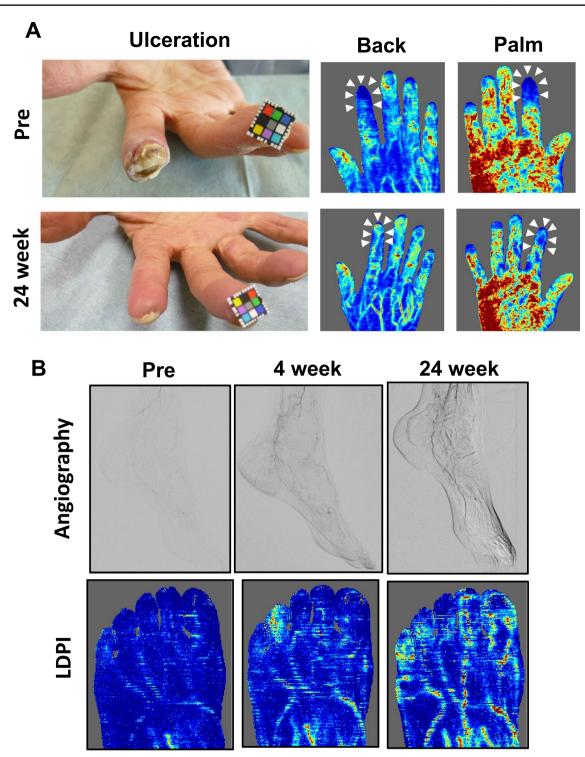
Time courses after ADRC implantation (A) improvements in non-healing ulcer and blood perfusion recovery in a case of the 63 years' upper limb ischemia patient. B Laser Doppler blood perfusion analysis and angiography in the 74-years-old CLI patient due to CTD
